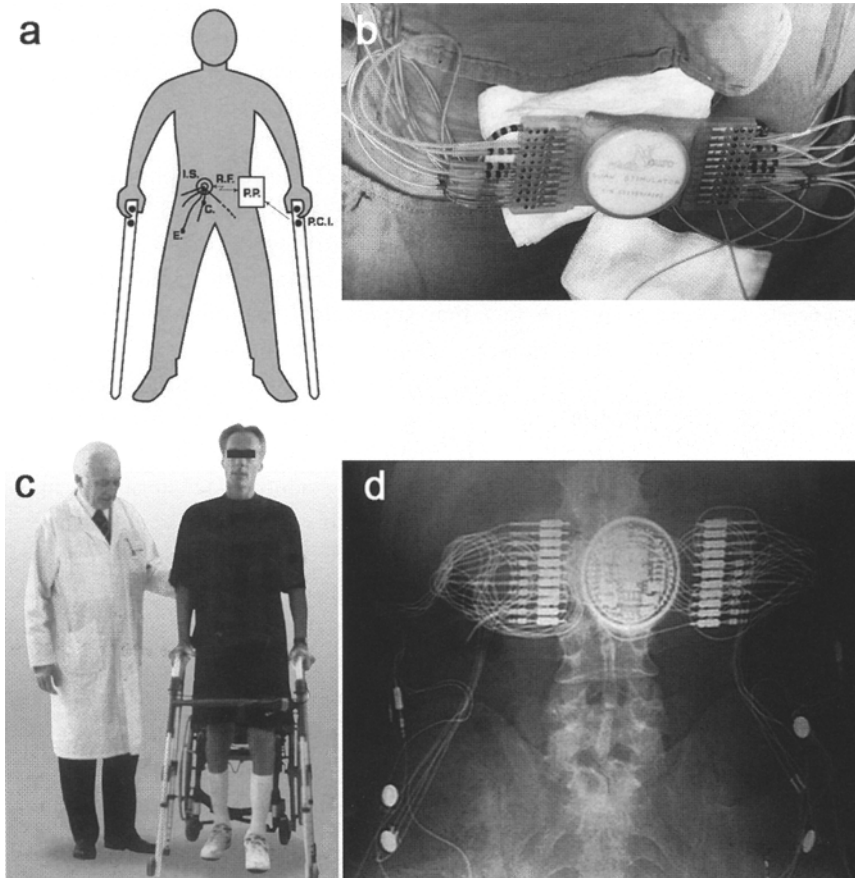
SUAW concept of implanted FES; (a) Sketch, (c) M.M. two weeks after implantation. (b) FES-neuroprosthesis with cables before and (d) after implantation (X-ray)
